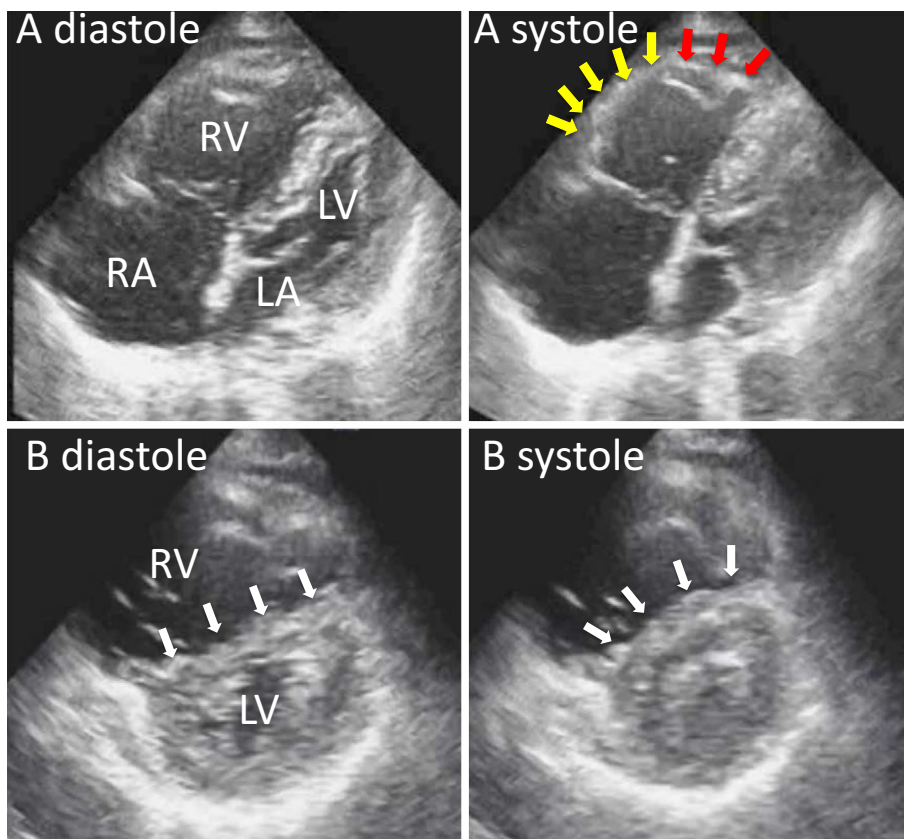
Echocardiography images obtained on admission. Apical four-chamber view of the heart during diastole and systole indicates right ventricular (RV) enlargement and free-wall systolic ballooning (yellow arrow) with apical motion sparing (red arrow). The left ventricle (LV) is small and no regional wall motion abnormalities are apparent (A). Parasternal short axis view of the heart during diastole and systole reveals RV enlargement. The interventricular septum (IVS) is flattened during diastole (white arrow), but not during systole, indicating a change in the volume without any superimposed pressure overload (B). LA: left atrium, LV: left ventricle, RA: right atrium, RV: right ventricle
